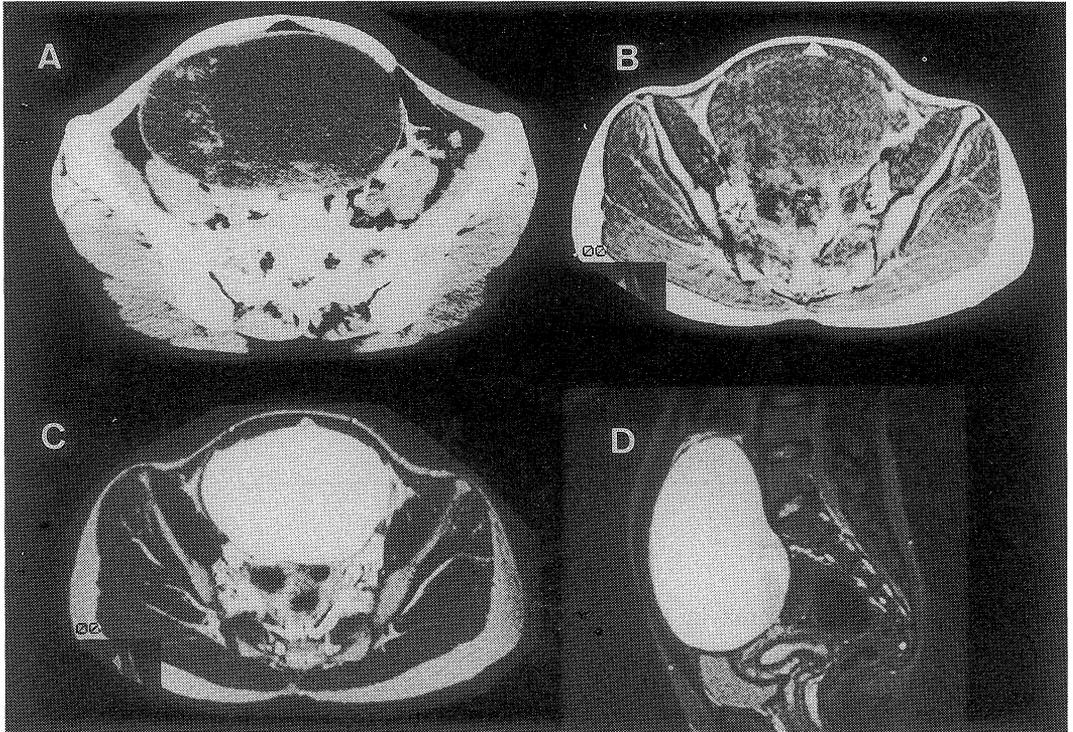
A : CT scan of the pelvis.
